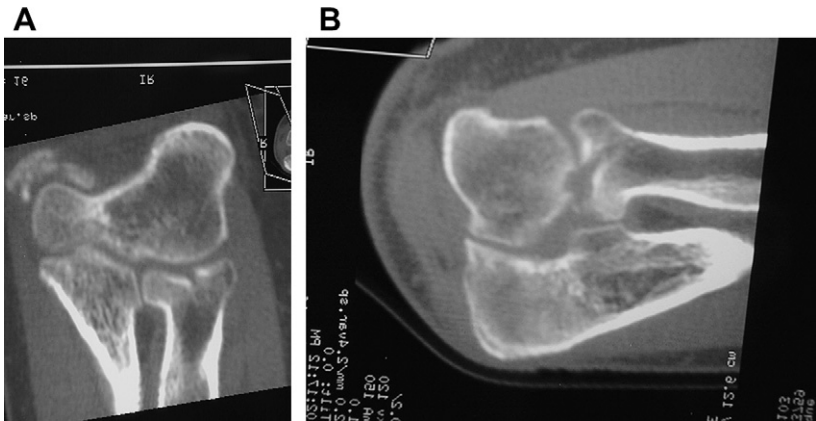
(A) Anteroposterior and (B) lateral radiographs of radiocapitellar post-traumatic arthritis after radial head fracture.
